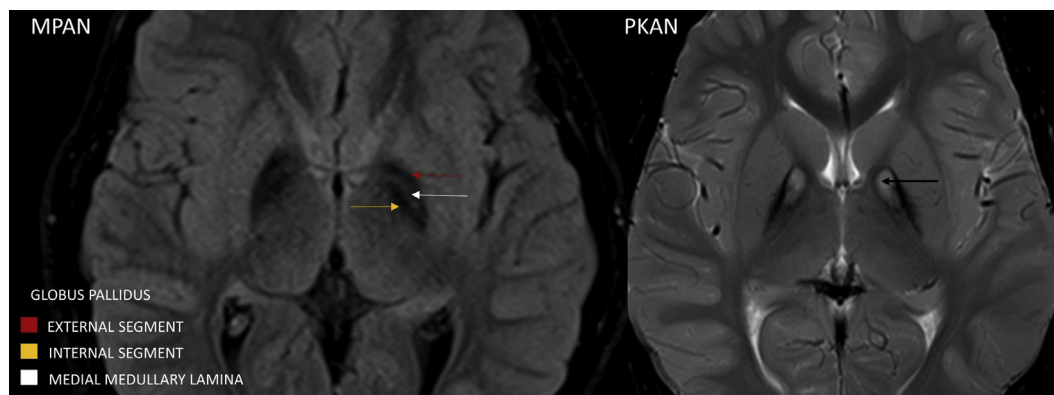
Axial FLAIR imaging (A) shows hypo intensity of the internal and external segments of globus pallidus with faint hyper intensity of the medial medullary lamina separating them. The typical appearance of PKAN on T2 axial image (B) shows bilateral symmetric globus pallidus hypointensity. The central hyperintensity (black arrow) in comparison to MPAN is more rounded and hyperintense and does not confine to the medial medullary lamina.
